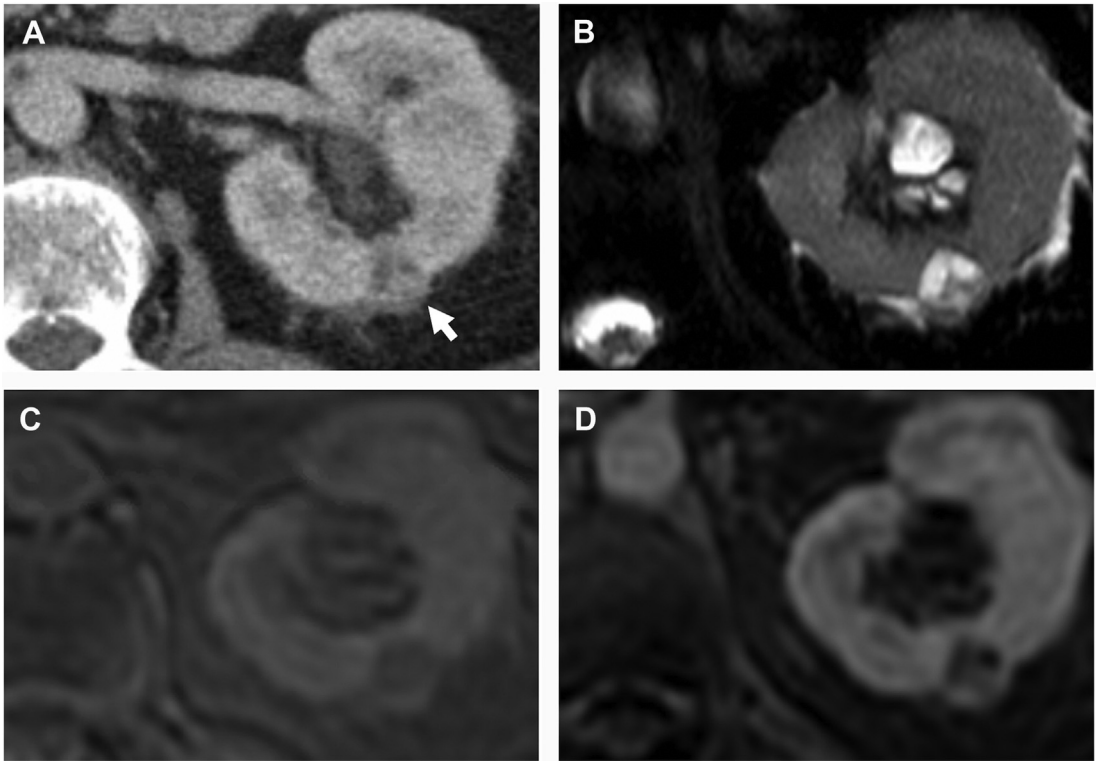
A 58-year-old woman with a 1.1-cm heterogeneous left renal mass on a portal venous CT scan that is TSTC (arrow, A). This lesion was indeterminate owing to heterogeneity and further evaluated by renal MR imaging and found to be hyperintense with septations on T2-weighted imaging (B), hypointense on pre-contrast T1-weighted fat-saturated images (C), and had enhancing septations on post-contrast T1-weighted fat-saturated images (D). The lesion was characterized as a Bosniak type IIF renal cystic mass.
